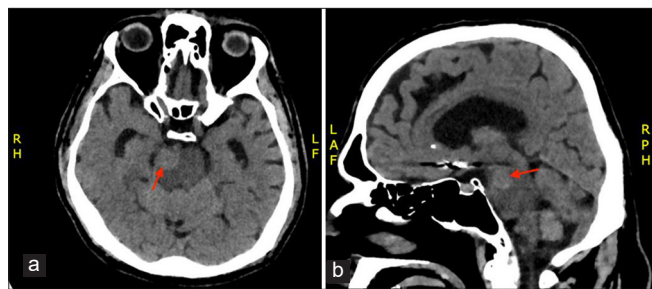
Postoperative CT of the brain (a: axial; b: sagittal) without contrast showing expected postsurgical changes, a grossly intact brainstem lesion (red arrows) and a prior embolization of an anterior communicating artery aneurysm.
